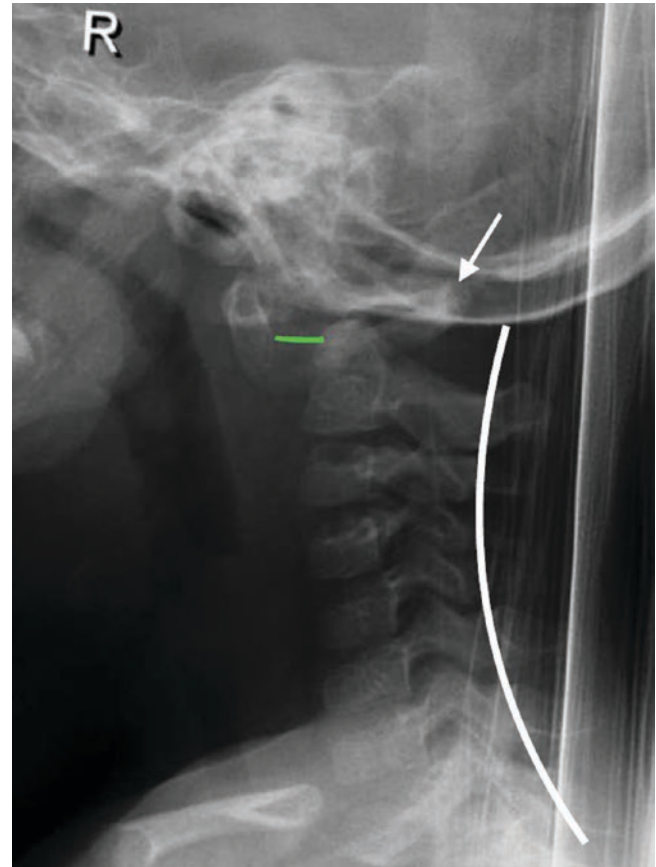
Atlanto-axial dislocation. Lateral cervical spine radiograph demonstrates anterior movement of C1 relative to C2 and widening of the atlantodens interval (ADI, green line). There is interruption of the spinolaminar line (white curve), with the spinous process of C1 (arrow) lying anterior to the line. Prevertebral soft tissue swelling is present
